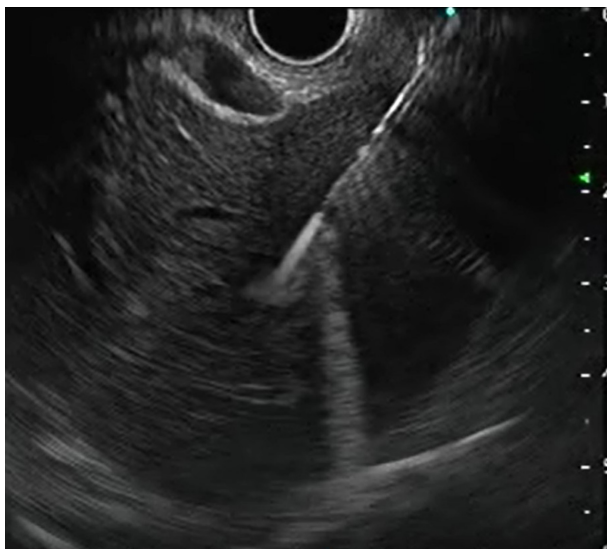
Endoscopic ultrasound-guided liver biopsy.
